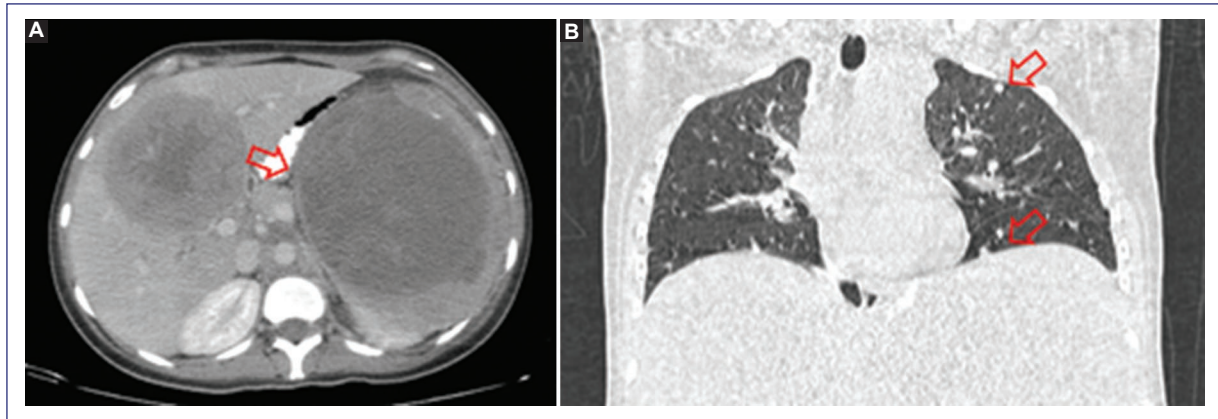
Computed tomography showing on A: axial section, a tumor arising from the left kidney measuring $18.5 \times 14.6 \times 13.3$ cm in its greatest dimensions (arrow); a hepatic metastasis is also visualized. B: pulmonary metastases are identified in the left apical and basal regions (arrows).
